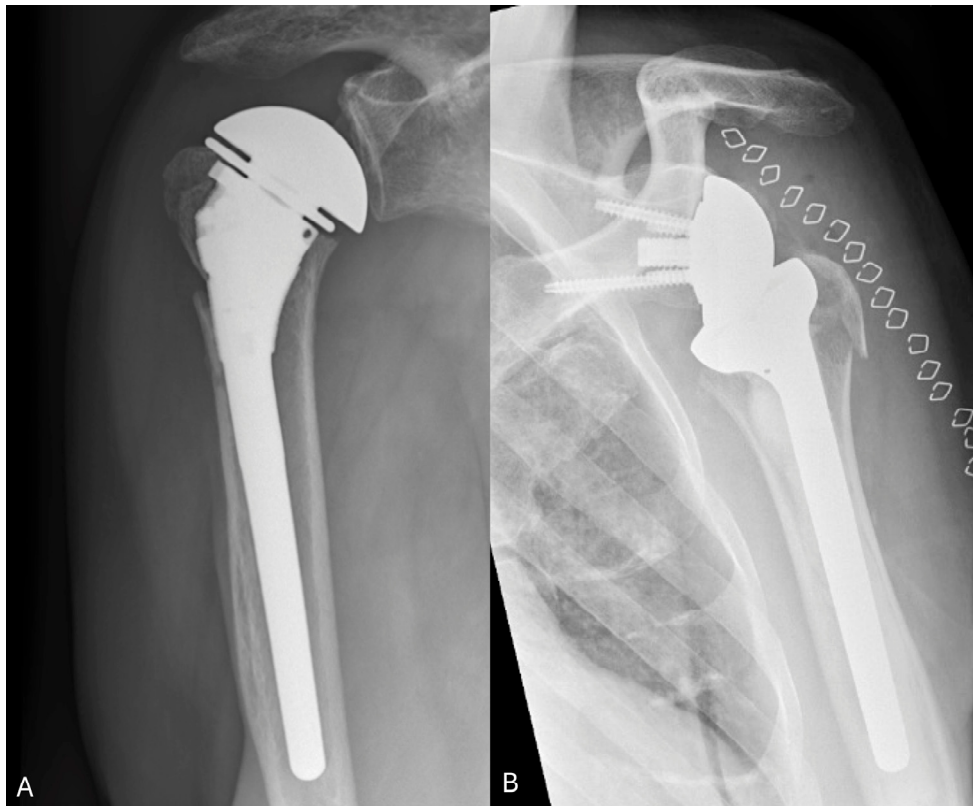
Shoulder prostheses. Two alternatives for shoulder prostheses following a proximal humeral fracture. A: Hemi-arthroplasty, non cemented. B: Reversed shoulder arthroplasty, cemented stem. Skin staples are still present, and visible, on this early postoperative radiograph. Radiographs photographed by the author.
